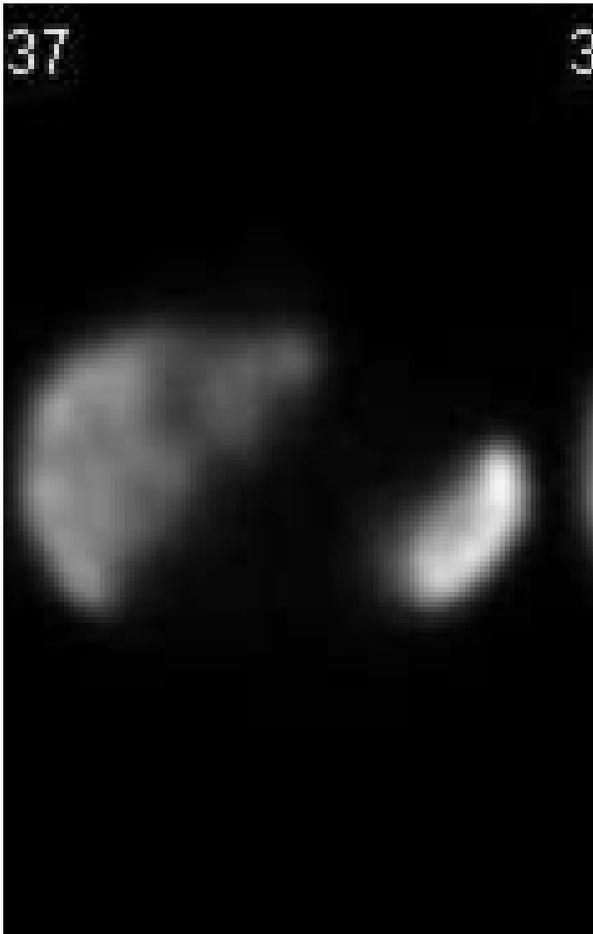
A 45 year-old woman with Graves' disease post I-131 therapy remained mildly hyperthyroid and had the axial SPECT shown above on the right. Her abdominal ultrasound confirmed diffuse fatty liver although her BMI was normal at 23.8 and she had normal serum transaminases. In fact, less than 28% of all our patients with abnormal Sn had abnormal transaminases. Her Sn value of 1.863 was typical of NAFL although she would otherwise have been considered normal: in fact it generally was observed cf. Fig 5 that patients with thyroid disease had one category more abnormal Sn than would otherwise have been expected if their thyroid was normal.
